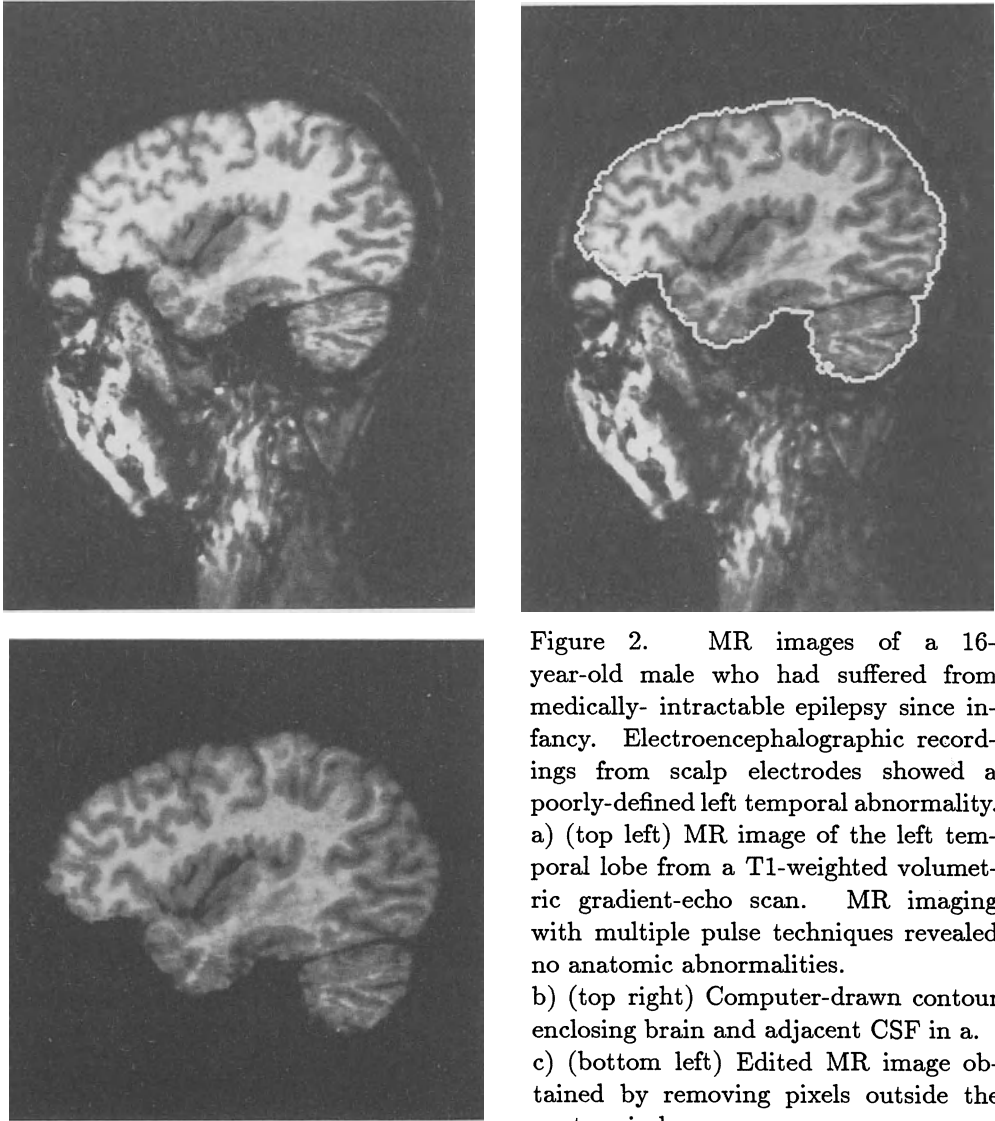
MR images of a 16-year-old male who had suffered from medically- intractable epilepsy since infancy. Electroencephalographic recordings from scalp electrodes showed a poorly-defined left temporal abnormality. a) (top left) MR image of the left temporal lobe from a T1-weighted volumetric gradient-echo scan. MR imaging with multiple pulse techniques revealed no anatomic abnormalities. b) (top right) Computer-drawn contour enclosing brain and adjacent CSF in a. c) (bottom left) Edited MR image obtained by removing pixels outside the contour in b.
